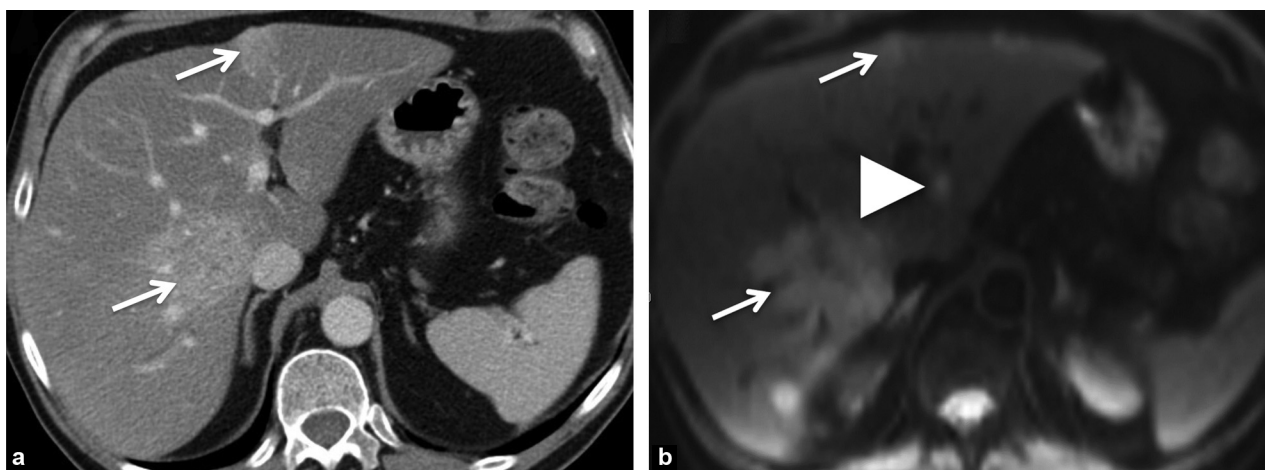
a: axial contrast enhanced portal phase CT scan of the liver shows the presence of two metastases (thin arrows); b: diffusion MRI ($b = 100 \text{ sec/mm}^2$): discovery of an additional metastasis in segment 2 (arrowhead).
